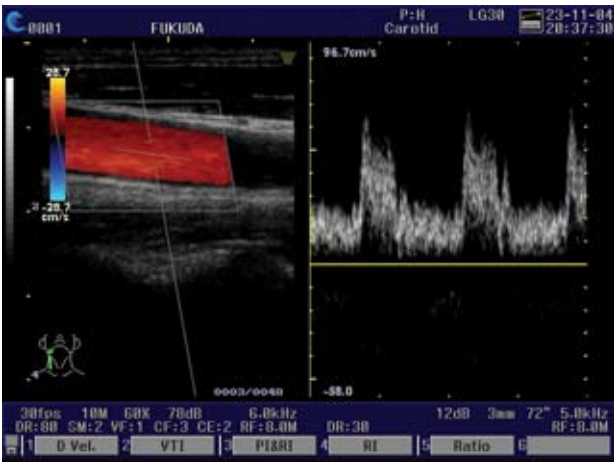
Color Doppler image of the common carotid artery shows widely patent vessel with normal spectral Doppler flow.
